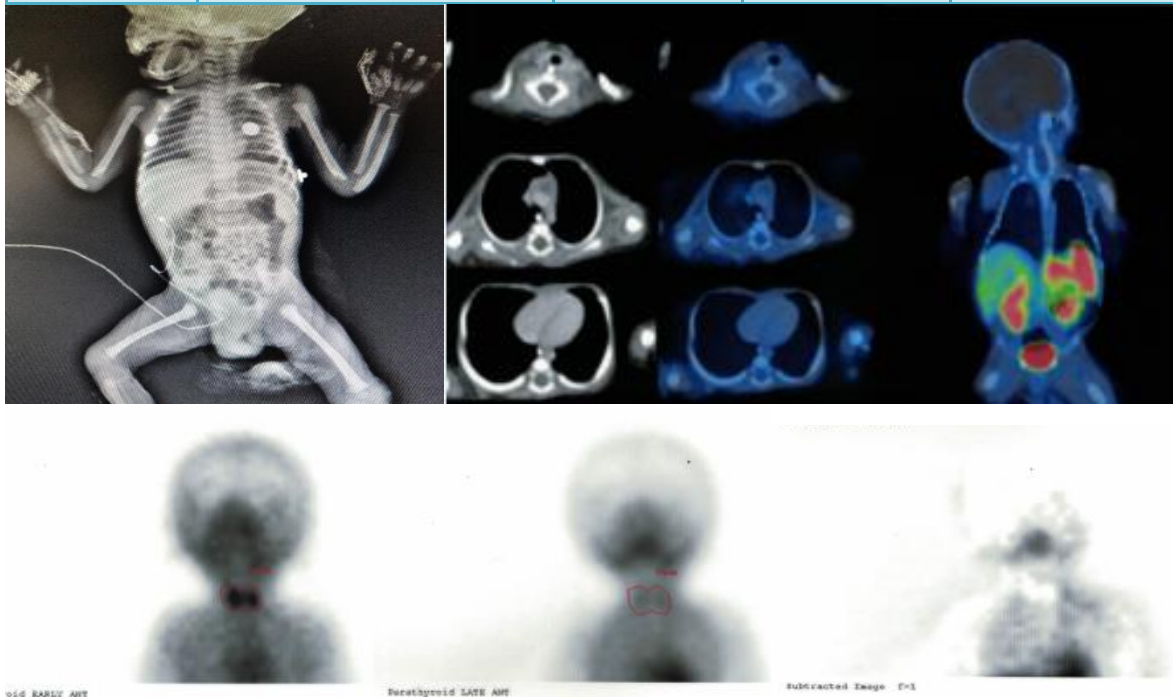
Infantogram (1A), Ga-68 DOTANOC PET CT scan – no evidence of abnormal somatostatin receptor expressing lesion anywhere in the body, no evidence of parathyroid adenoma on this study (1B) and ^{99m}Tc MIBI parathyroid scan–normal study, no evidence of parathyroid adenoma (1C).
